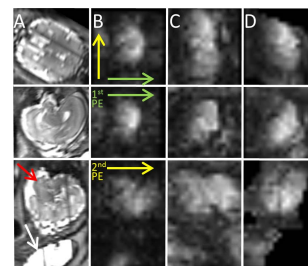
fetal images along orthogonal planes: (A) anatomical T2-weighted image showing the fetal brain (red arrow) and the mother's bladder (white). (B) 3D-EPI with PB excitation. (C) EVI. (D) EVI after distortion correction along the slow phase encode direction. Phase encode directions shown in green (fast) and yellow (slow).
